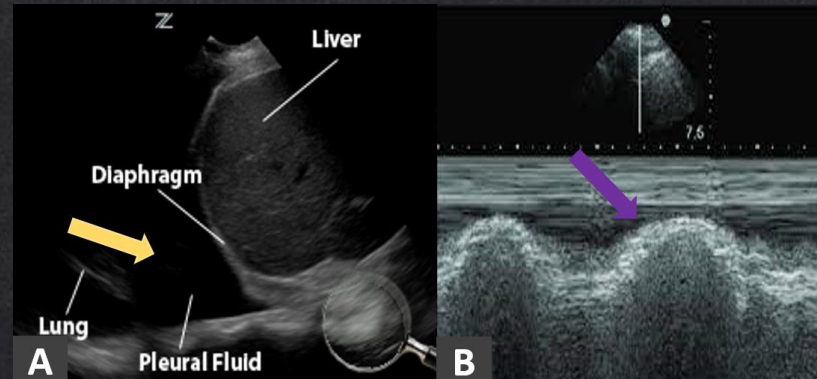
73-year-old man presents with dyspnea. Lung ultrasound shows an anechoic collection in right pleural space, compatible with pleural effusion in B mode (A) - (yellow arrow) and in M mode where there is the sinusoid sign (B) - (purple arrow). This finding is a dynamic sonographic sign, present when respiratory variation decreases the distance between the parietal and visceral pleura, when separated by a pleural effusion.
